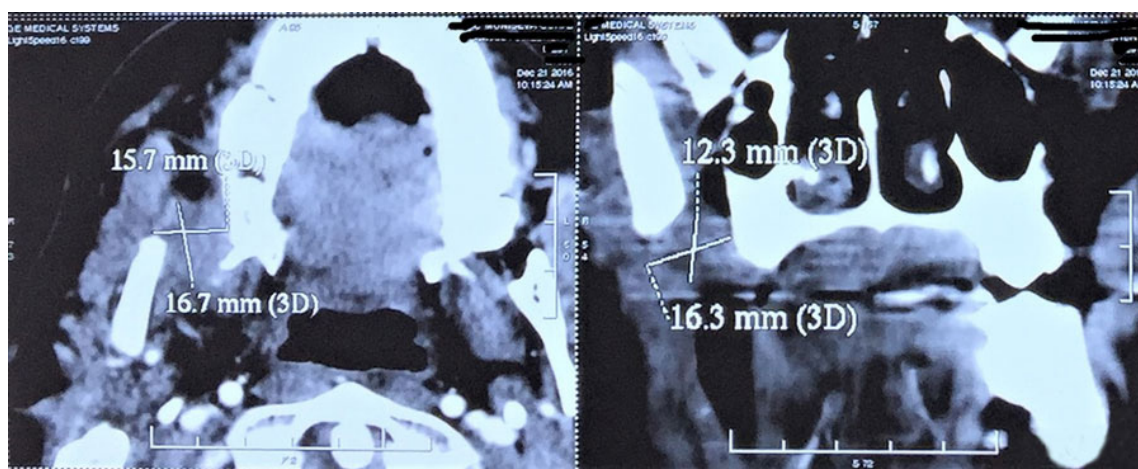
Computed tomography showing the local recurrent lesion at the flap site
